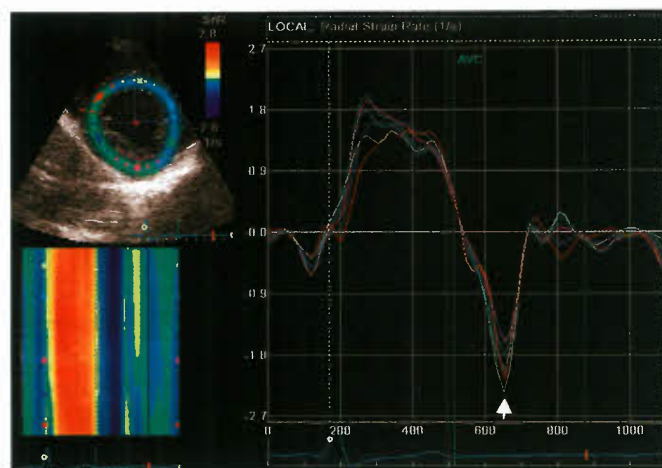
Left ventricular early diastolic radial strain rate obtained from 2-D speckle-tracking echocardiography in a parasternal short-axis plane at the papillary muscle level. Peak early diastolic strain rate is marked by the arrow. The top left panel is the reference image. The lower left panel depicts strain rate in color M-mode format. The x-axis is time. The y-axis is the various myocardial segments with the top portion indicating the anterospetum and continuing clockwise (around the transverse plane of the LV from top to bottom in the figure). The blue color depicts the diastolic strain rate and gives the same information shown in the curves. Although, this measurement reflects early diastolic relaxation, we do not advocate for its use as a routine clinical parameter as frame rates are low compared to the rapid sequence of the event.
